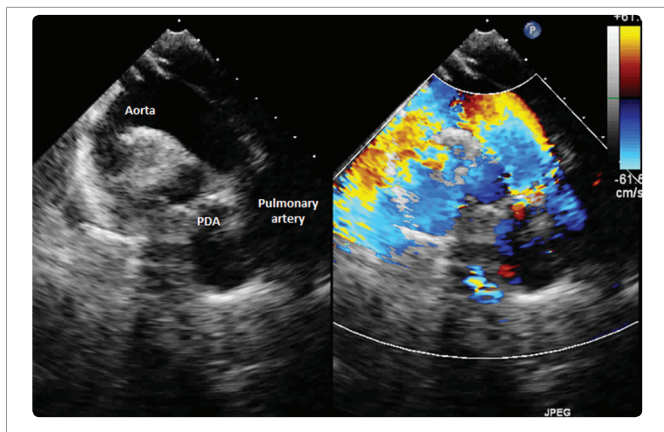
Transthoracic two-dimensional color Doppler echocardiogram showing continuous wide flow from the aorta through the ductus to the pulmonary artery.
